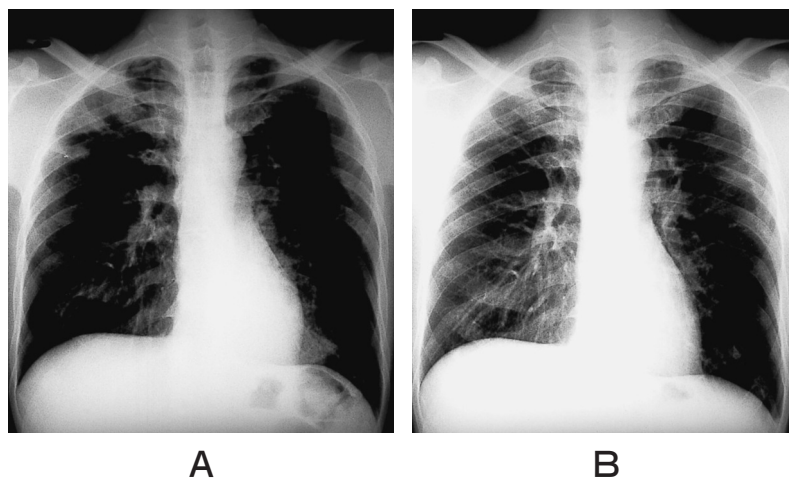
A, a chest roentgenogram obtained on admission reveals infiltrative shadows partly including particulate shadows in the right upper and left lower lung fields of case 1. B, a chest roentgenogram after corticosteroid therapy revealed a marked improvement in case 1.
